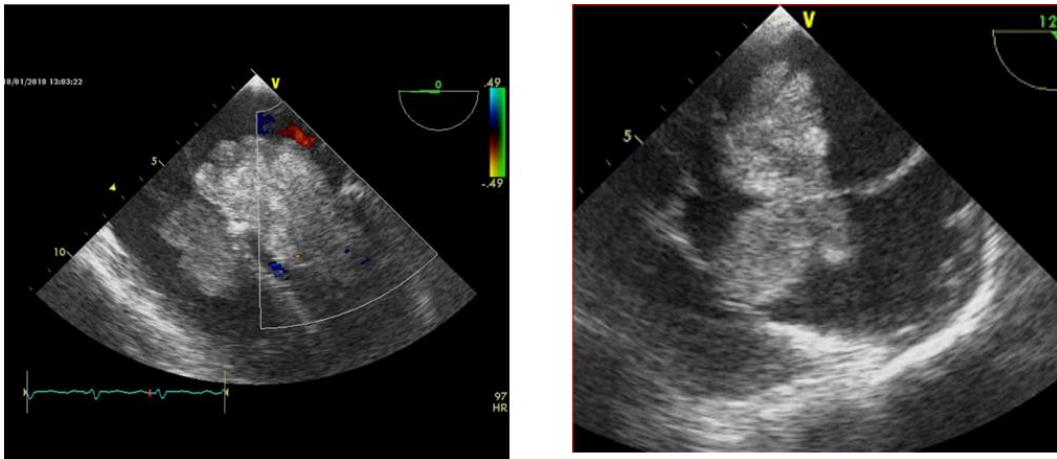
Transoesophageal echocardiogram showing typical butterfly-shaped biatrial myxoma.
